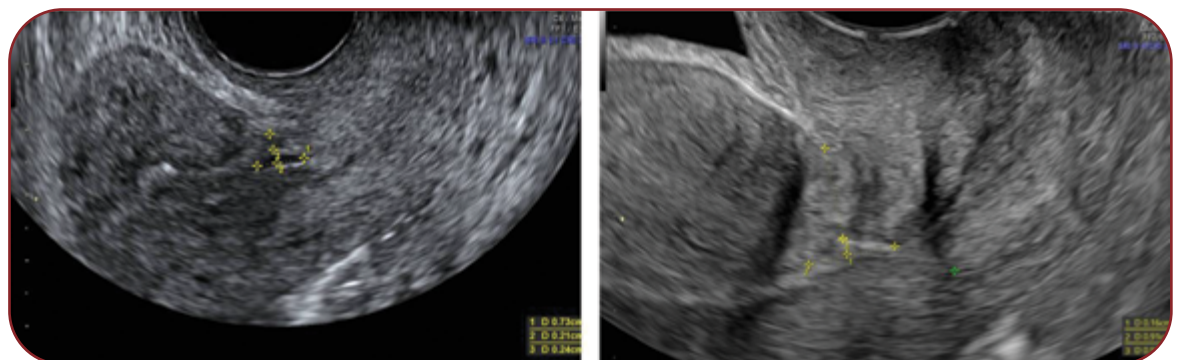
Preoperative and postoperative images of transvaginal ultrasound for a case of cesarean scar defect (CSD) – sagittal view indicating measurements of residual myometrial thickness (RMT) along with the base and height of the defect before surgery in the left image and after four months of follow-up on the right side
